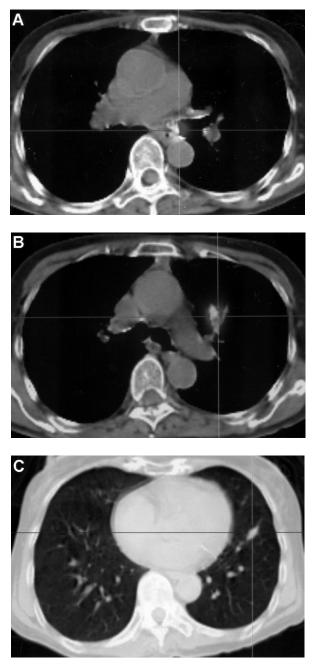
PET/CT of the 3 areas in the left lung (A) A 1.3-cm left main bronchial mass with FDG uptake (SUVmax=9.5) (B) A 1.0-cm left upper lobe soft tissue opacity with FDG uptake (SUVmax=8.8) (C) A 1.4-cm left lower lobe nodule without FDG uptake
